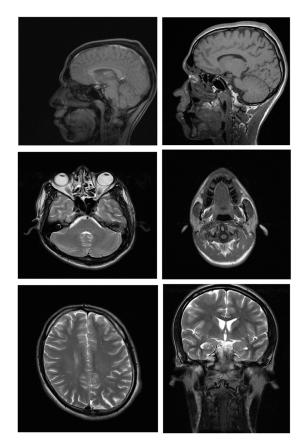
Magnetic resonance imaging (MRI) scans of the head and neck region with 3M Unitek Clarity SL ceramic self-ligating brackets with metal slots
